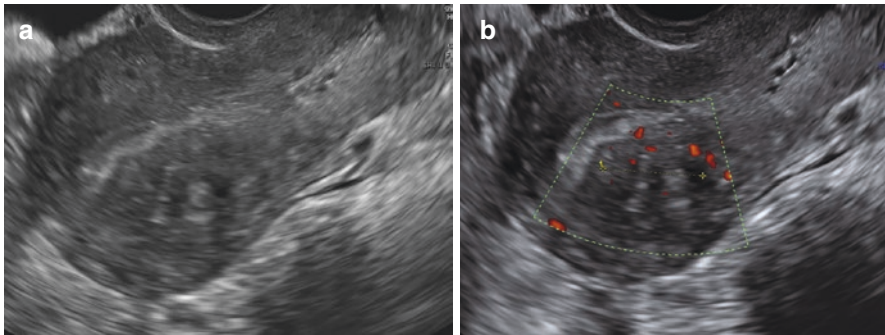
(a, b) Ultrasound images of focal adenomyosis of the posterior uterine wall not involving JZ but only the outer myometrium; note the hyperechoic area and the intramyometrial cysts. (b) Power Doppler image showing diffusely spread small vessels
